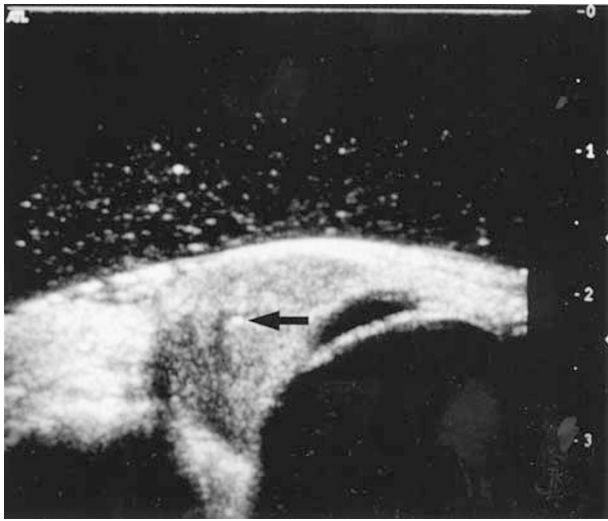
Ultrasound scan of haemangioma showing intermediate echogenicity, homogenous texture and a phlebolytic (arrow).
